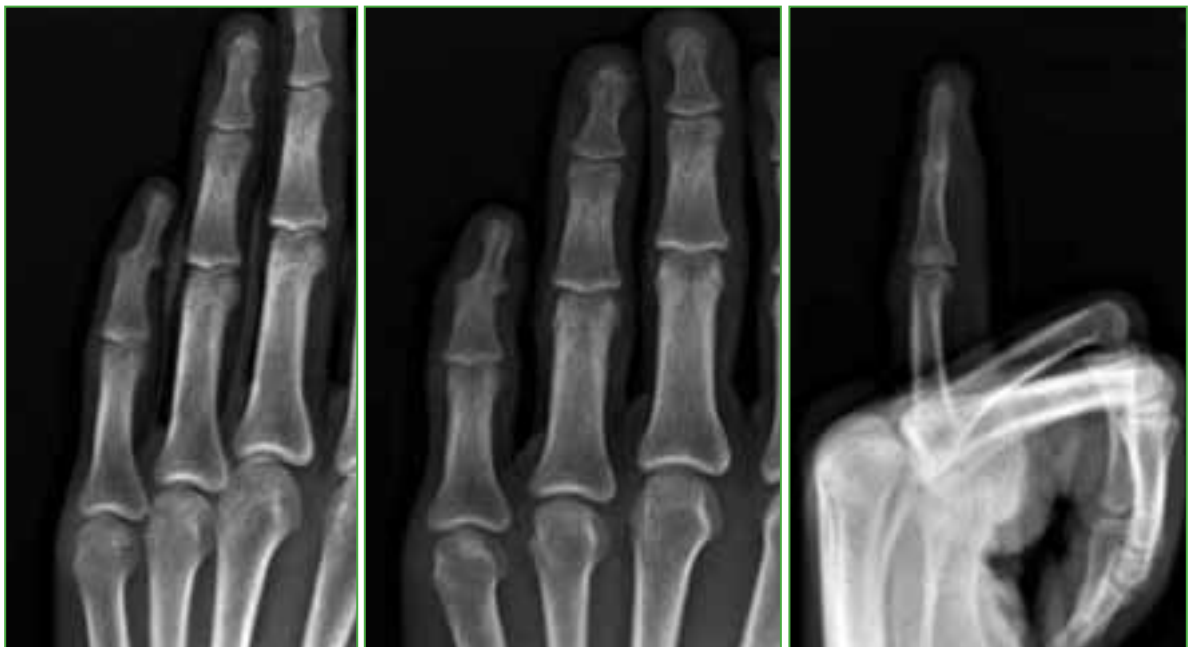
X-ray, 2 months after surgery. X-ray showing consolidation of the distal interphalangeal joint arthrodesis.
